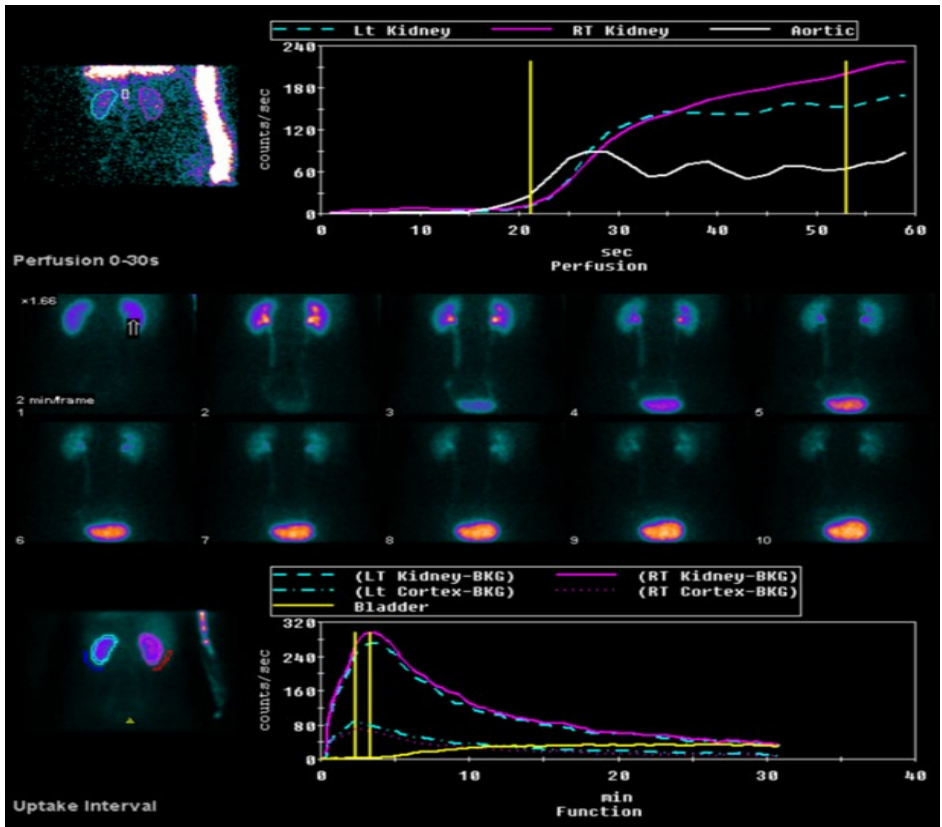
Renal scintigraphy scan with radioisotope Tc- 99m MAG₃ perfusion curves.
